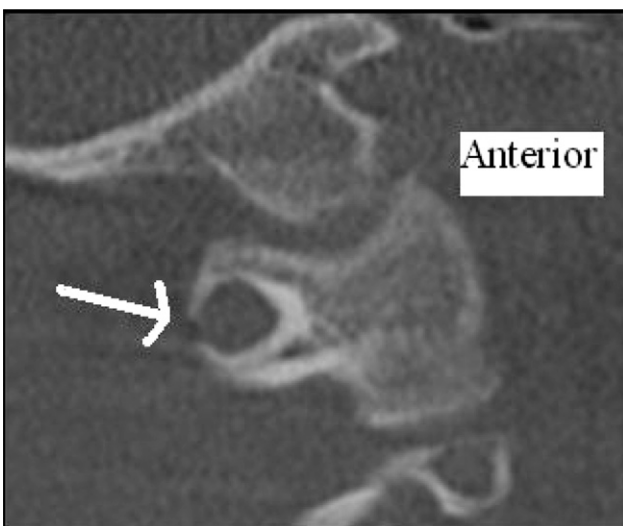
Cone beam CT sagittal section depicts a Class 3 ponticulus posticus on the right side (arrow). The patient is a 14-year-old black male.
